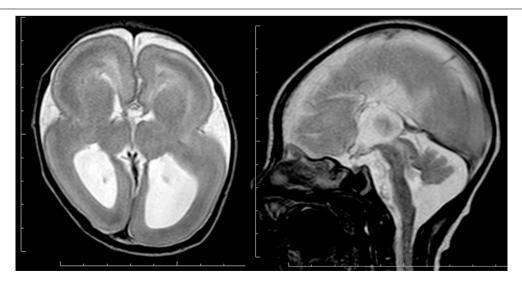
Complete agyria in a *TUBA1A* mutation patient (Grade 1 on the severity scale). T2-weighted axial MRI image (left) and midsagittal image (right). The boundary of the caudate nucleus and lentiform nucleus is obscure. Complete agenesis of the corpus callosum and pontocerebellar hypoplasia are also seen.
